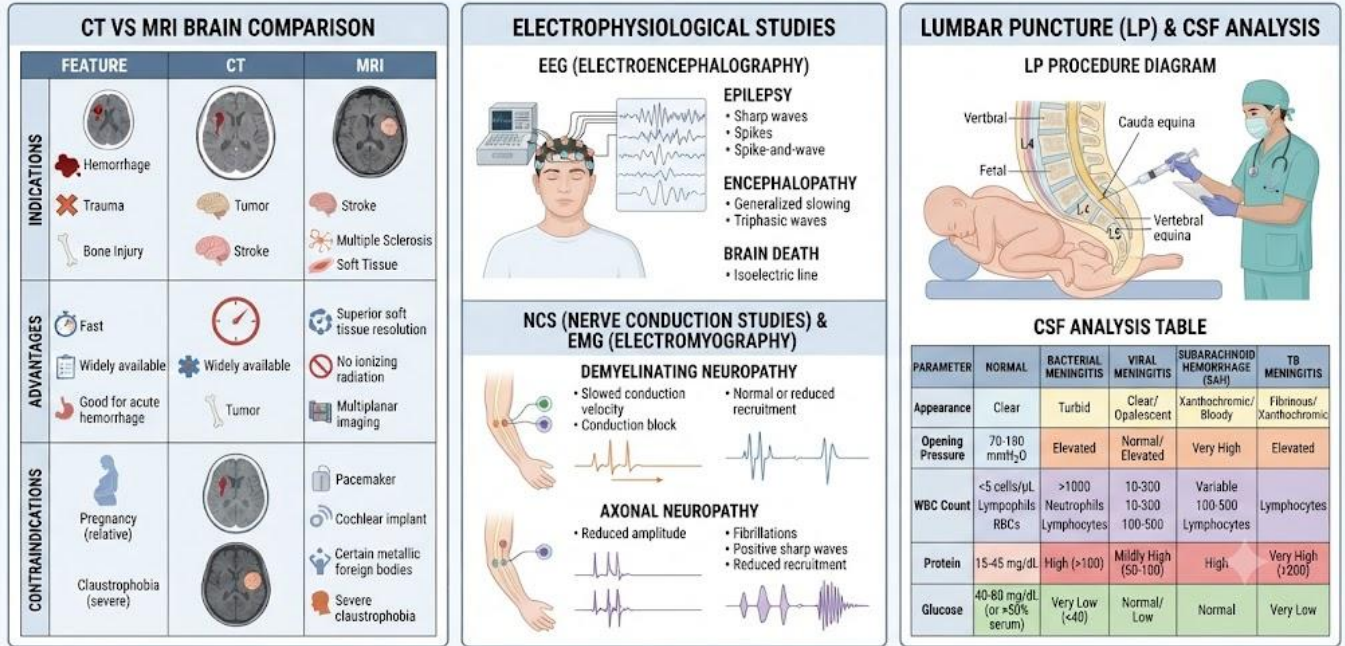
Neurological investigations: CT and MRI, electrodiagnostic tests, and CSF analysis
